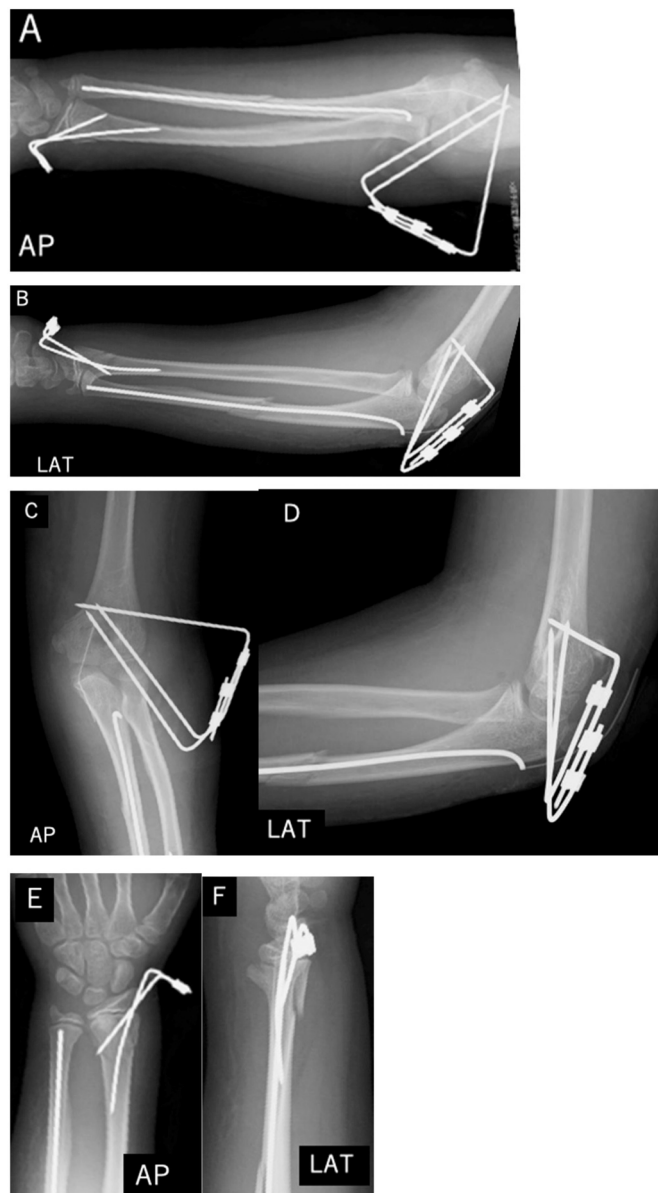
Postoperative X-rays. Left forearm (A: frontal image, B: lateral image), left elbow joint (C: frontal image, D: lateral image), left wrist joint (E: frontal image, F: lateral image). The reduction position of the humeroradial joint and each fracture site is good.
